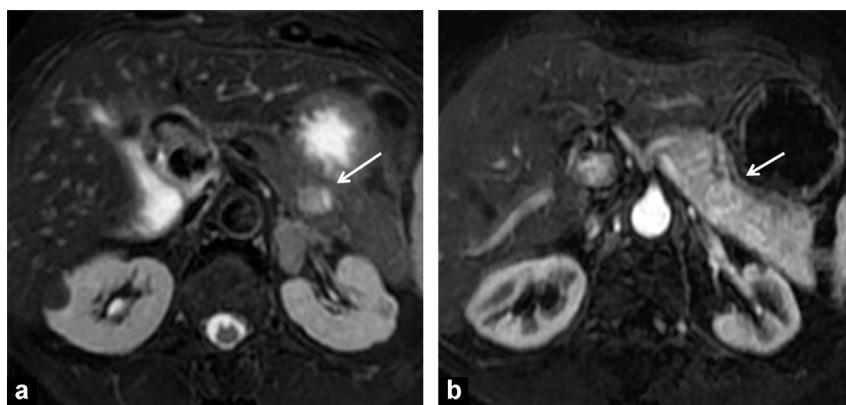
Small functioning pancreatic neuroendocrine tumor. T2-weighted MR image (a) shows a small lesion with well circumscribed margin and high signal intensity (arrow). On T1W acquired after contrast during the arterial phase, the lesion enhances with a rim like enhancement (arrow). Note that this hypervascularized PNET is better depicted on T2W because of the high enhancement of the pancreas in the arterial phase, which concealed hypervascular tumours.
